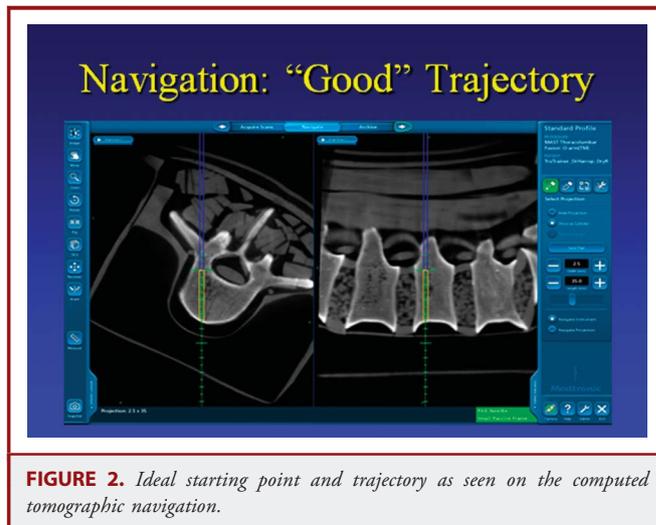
Ideal starting point and trajectory as seen on the computed tomographic navigation.
